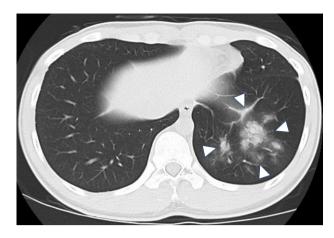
CT showed left acute pneumonia on the dorsal side of the left lung. The arrow heads indicated the lesion of infiltrative shadow.
